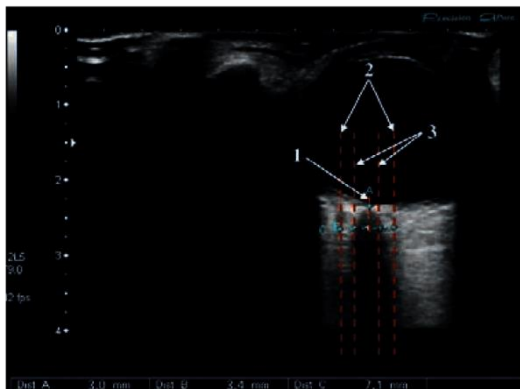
Visualization of the optic nerve by ultrasound. 1 — the point 3 mm behind the retina for assessment of ONSD; 2 — diameter of the sheath of the optic nerve; 3 — diameter of the optic nerve
